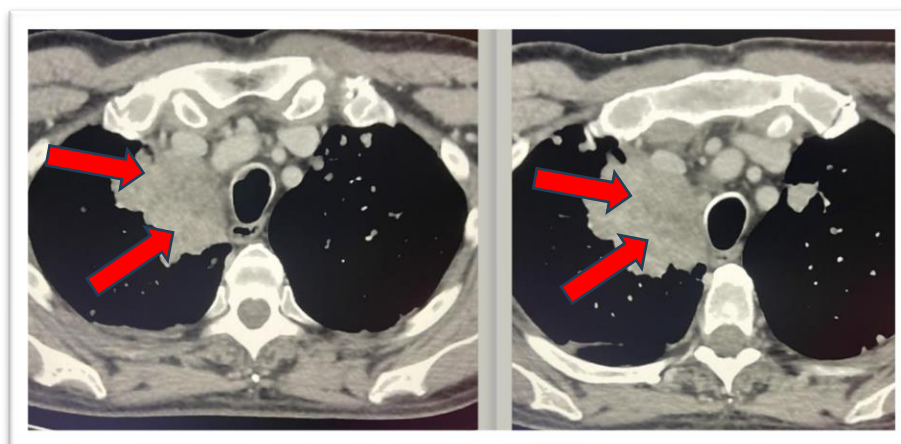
CT Staging: a bulky expansive process of the right lung (arrows).
